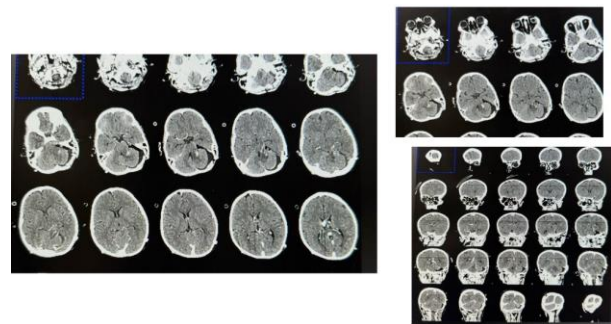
Post Op CT scan showing complete excision
